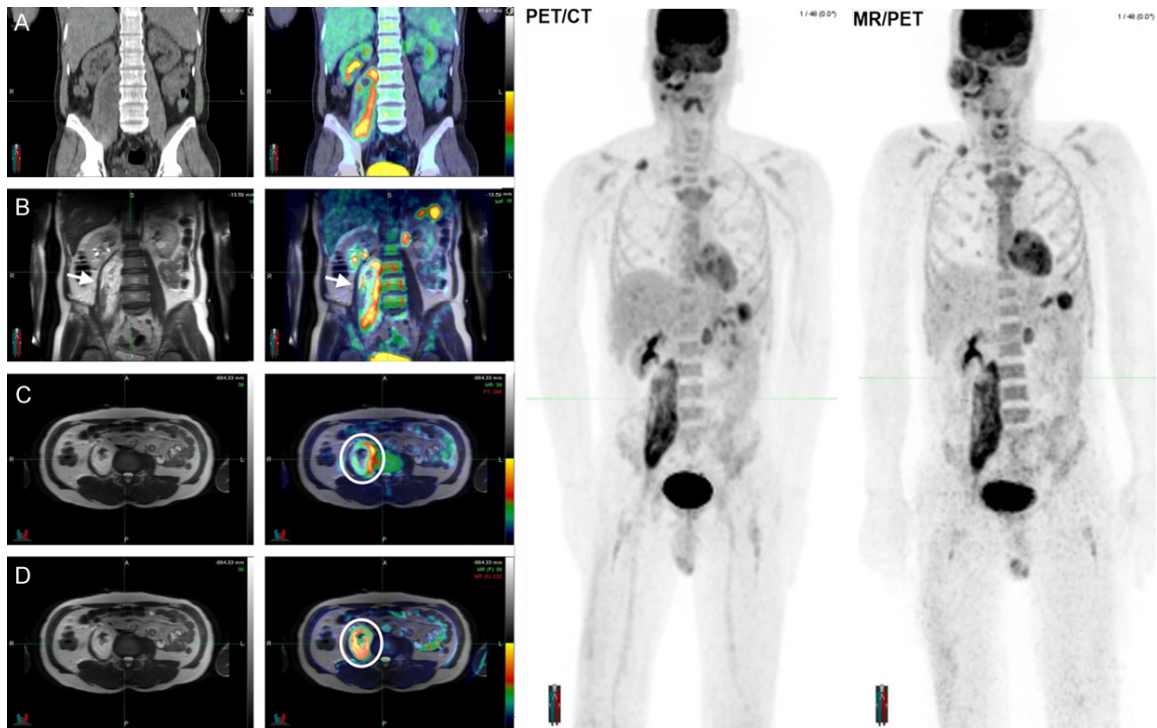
Coronal CT reconstruction (A) and coronal T2w (B) fused with their corresponding PET in the contiguous image (row A and B), reveals the higher soft-tissue resolution of MRI, allowing the identification of healthy muscle (arrow) that is displaced by the heterogeneous tumor. Axial T2w (C and D) fused with the corresponding PET (row C) and the DWI (row D) show the discrepant findings described in the text. Direct comparison of the PET MIPs shows the successful performance of PET/MRI and the MR based attenuation correction map.
